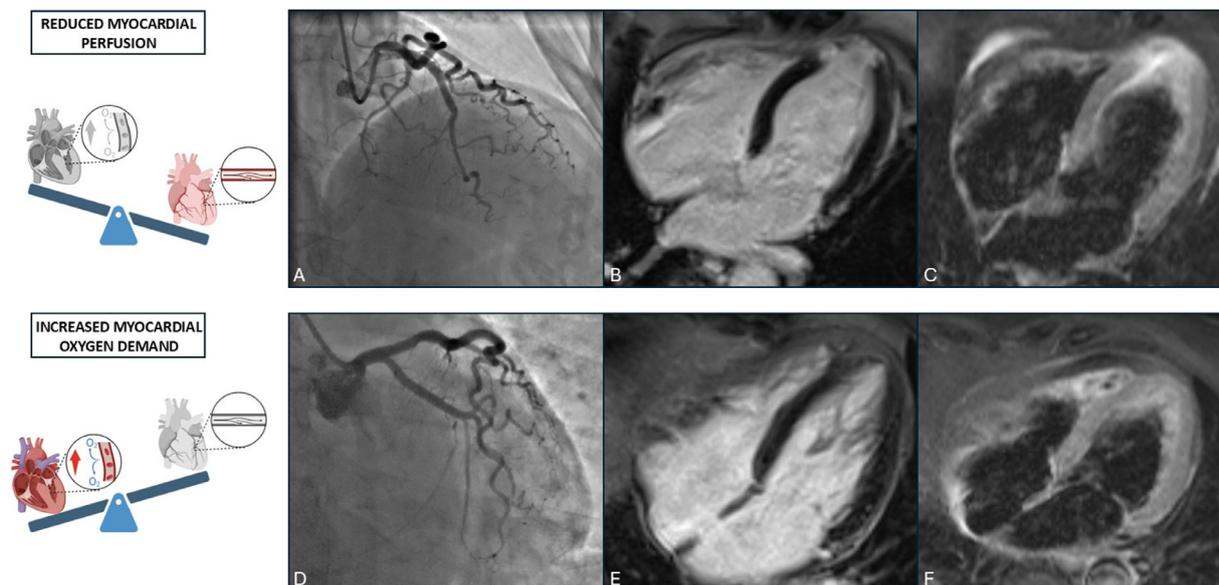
Examples of Type 2 Myocardial infarction. A) A 54-year-old female patient presented with a spontaneous, obstructive coronary artery dissection involving the distal left anterior descending artery, resulting in Type 2 myocardial infarction (T2MI). B) Late gadolinium enhancement (LGE) sequences demonstrated a transmural apical scar. C) T2-weighted short tau inversion recovery (T2-STIR) imaging revealed diffuse apical myocardial edema. D) No obstructive coronary arteries at coronary angiography in a 75-year-old female patient admitted for T2MI during new-onset atrial fibrillation with a rapid ventricular response. E) LGE sequences showed no evidence of myocardial scarring. F) T2-STIR imaging demonstrated diffuse, mild myocardial edema.
